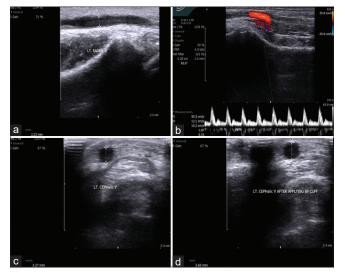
Preoperative assessment of vessels with duplex ultrasound. (a) Radial artery diameter measurement. (b) Radial artery peak systolic velocity measurement. (c) Cephalic vein diameter measurement. (d) Cephalic vein diameter after applying blood pressure cuff measurement
